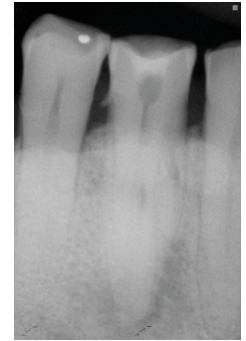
Diagnostic radiography
